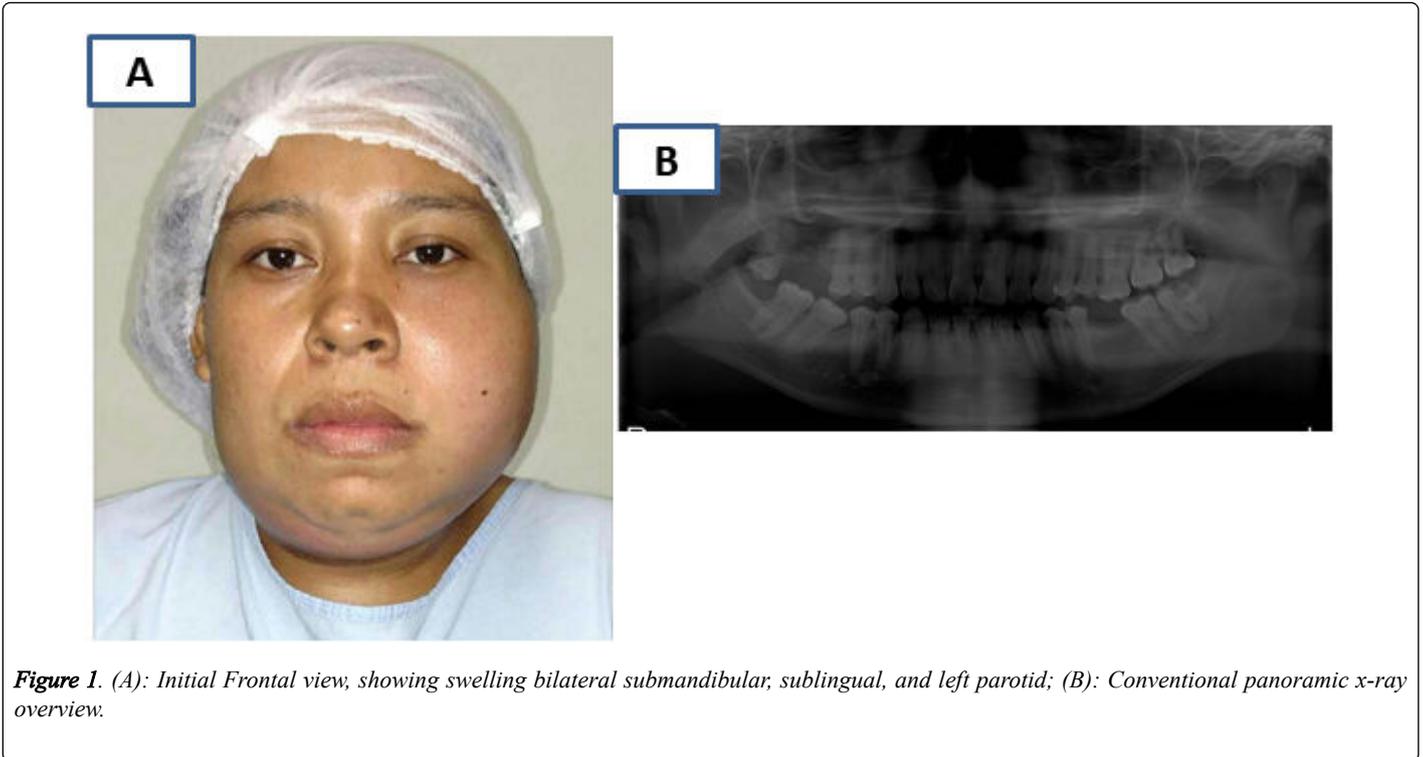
(A): Initial Frontal view, showing swelling bilateral submandibular, sublingual, and left parotid; (B): Conventional panoramic x-ray overview.
